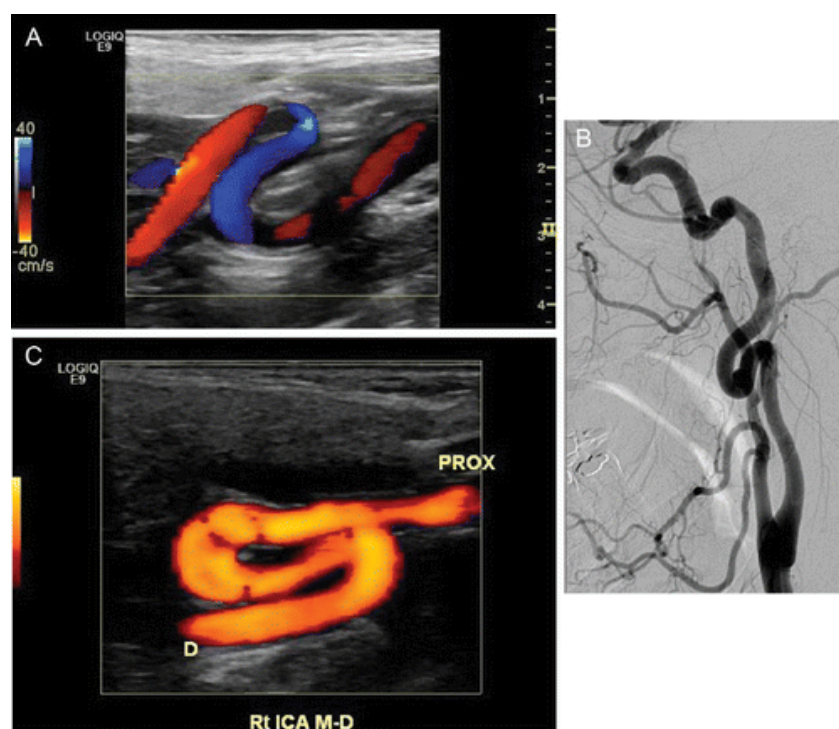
Carotid artery ultrasound images from two distinct patients A and C. The sonograms were performed on a GE LOGIQ E9 ultrasound machine [8]. The bilateral cervical internal carotid and vertebral arteries were imaged using a 9L-D linear transducer with a frequency of 9MHz in the sagittal plane [8].
